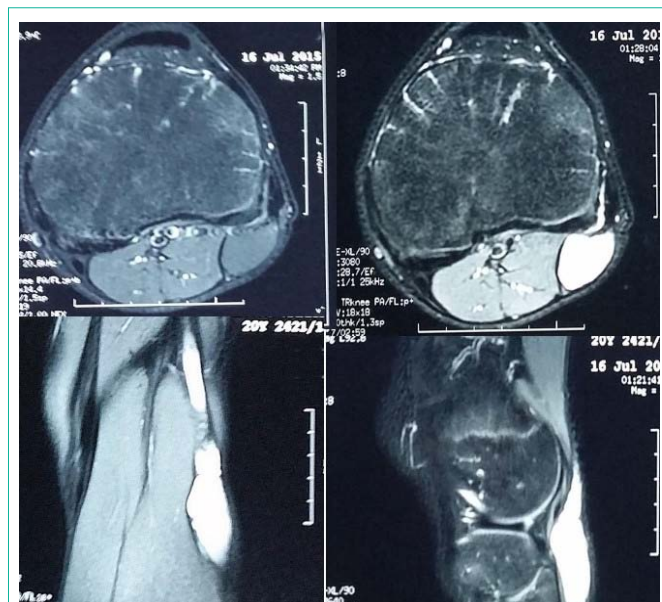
MRI showing a longitudinally oriented cystic lesion in the sciatic and common fibular nerve with extension towards the tibio-fibular joint.
